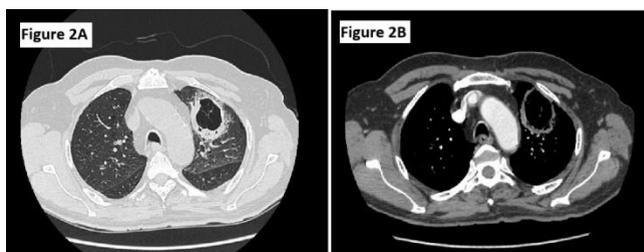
Contrast enhanced computed tomography images showing thick walled cavitory lesion in left upper lobe.
